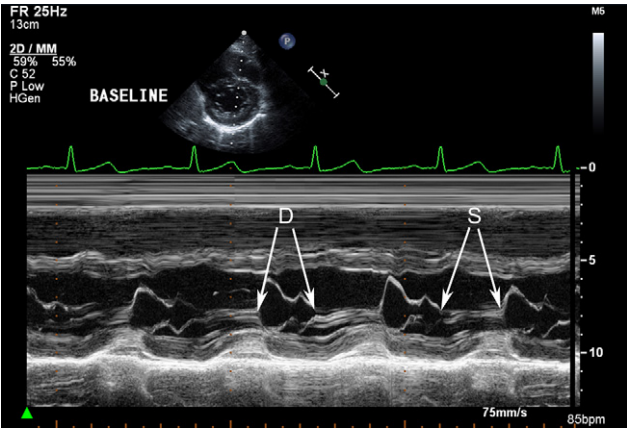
Parasternal short-axis view of the heart at the level of the mitral valve to examine closure (S) and opening (D) times in milliseconds to perform the S/D calculation. In this example, the patient is at baseline before exercise (rest).
